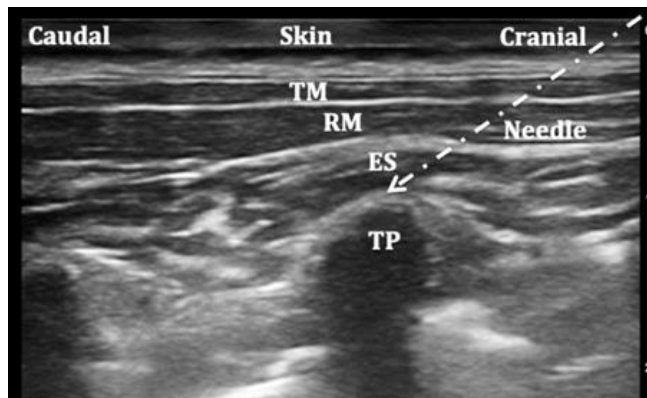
ultrasound image of the approach to erector spinae muscle.
